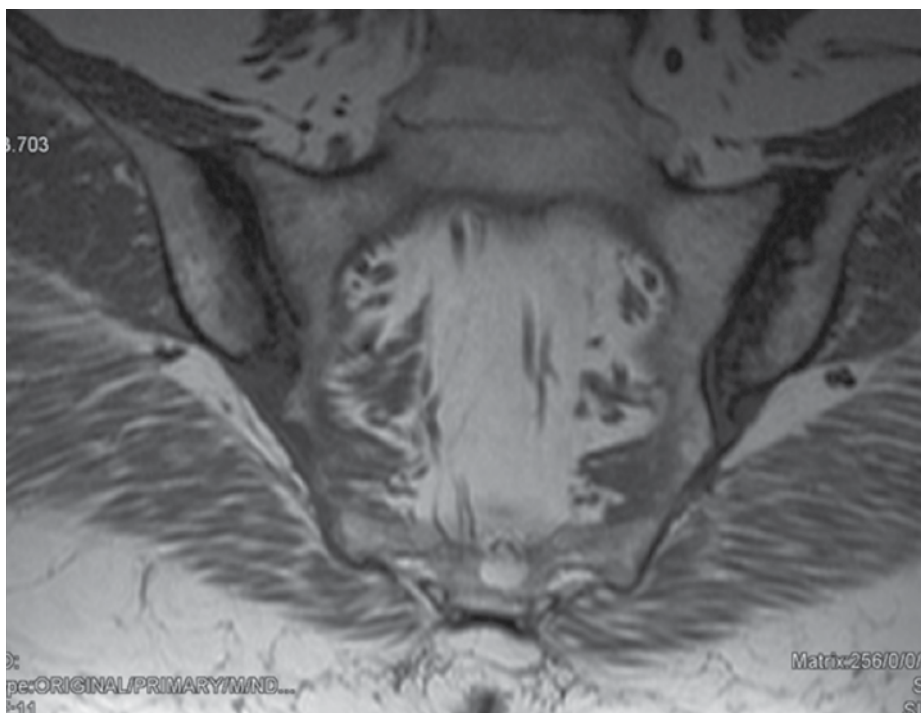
T1 weighted coronal MR image; there is subchondral sclerosis at the iliac sides of sacroiliac joints which represents chronic sacroiliitis
